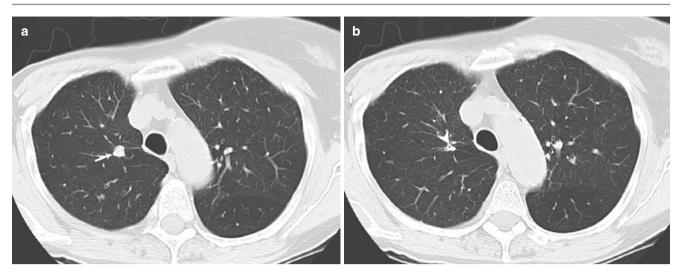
A 61-year-old woman with endobronchial metastasis. (a, b) Axial CT images show a 7 mm nodule (arrow) in right upper lobe located in the path of a subsegmental bronchus (arrowhead). Note right mastectomy
